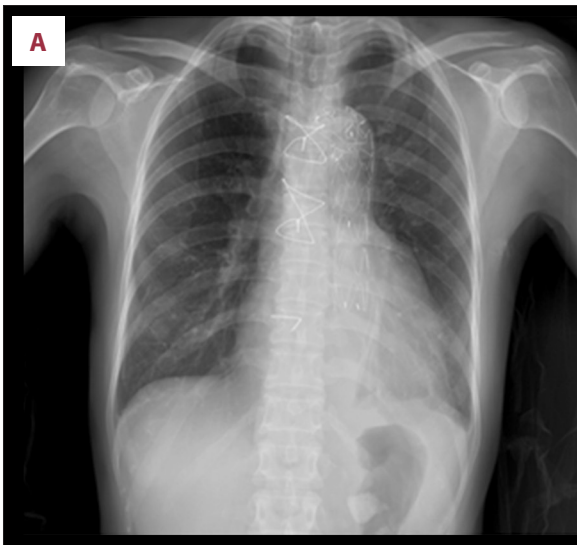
Chest X-ray on 3 days after TEVAR (A) and 7 days after TEVAR (B) showing the increased cardiothoracic ratio suggesting the presence of pericardial effusion.
